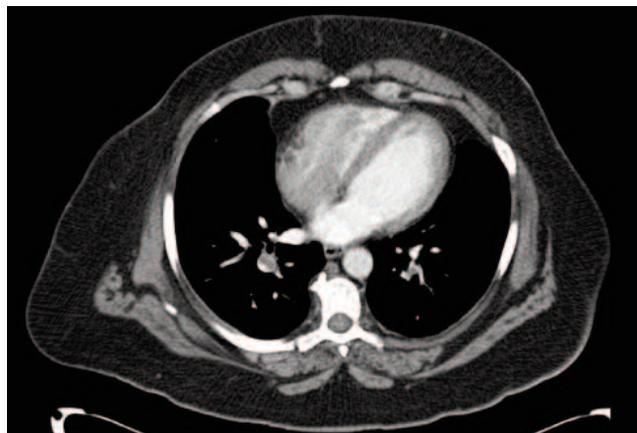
CT pulmonary angiography showing bilateral pulmonary embolism.
